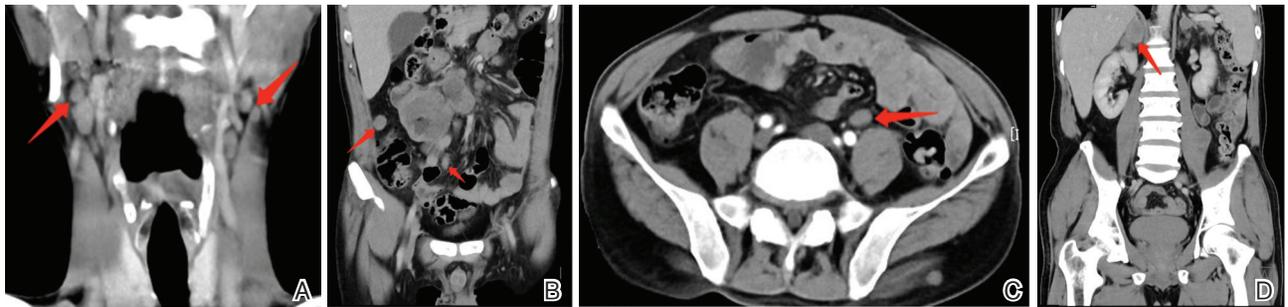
术后增强 CT 发现颈部、腹部、盆腔淋巴结转移
